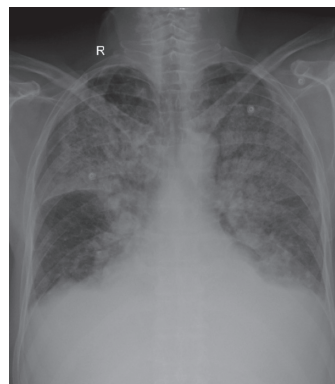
Chest X-ray on presentation.
